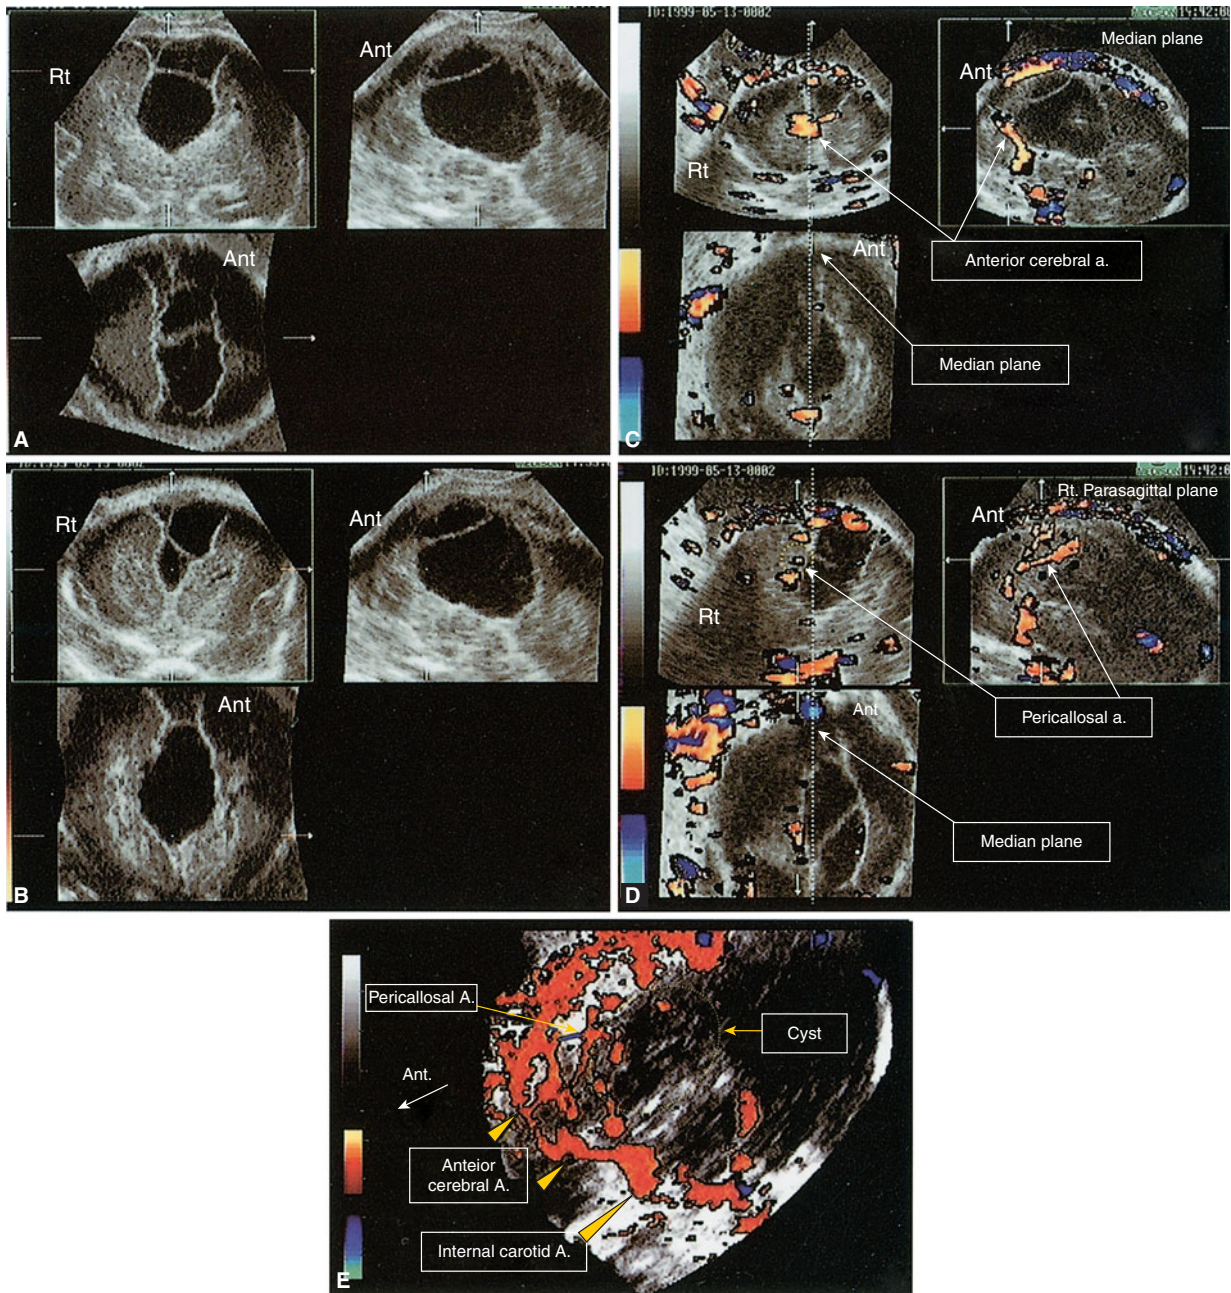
An arachnoid cyst originating from the quadrigeminal plate at 23 postmenstrual weeks. (A) The septated cyst displacing the falx to the right is shown by the coronal (box A), sagittal (box B), and axial (box C) planes. (B) Another set of orthogonal planes were selected to study the extent of the lesion. (C) Color Doppler study. The picture in the active box (box B) highlighted by the frame is generated in the median plane (dotted vertical white line through boxes A and C). Only the anterior cerebral artery, but not the pericallosal artery, is seen (the latter should be evident in this plane). (D) The plane is moved to the right. Now the active box (box B) is generated in the right parasagittal plane. In this plane, the pericallosal artery is clearly detected. This proves that the corpus callosum is not destroyed by the cyst. The dotted vertical white line was kept to mark the median plane. (E) A 3D color flow rendering of the anterior cerebral and pericallosal arteries. The approximate place of the arachnoid cyst is marked.
